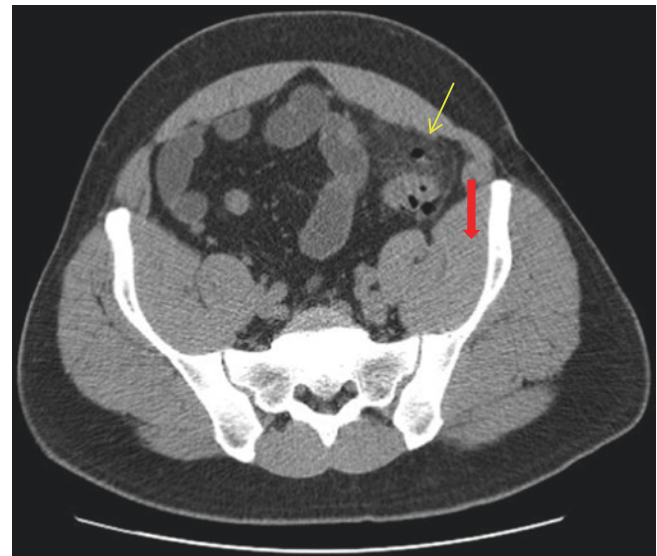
Western Trauma Association grade IA complicated diverticulitis. Computed tomography shows sigmoid diverticulitis (red arrow) with pericolic phlegmon and small focus of extraluminal air (yellow arrow)
